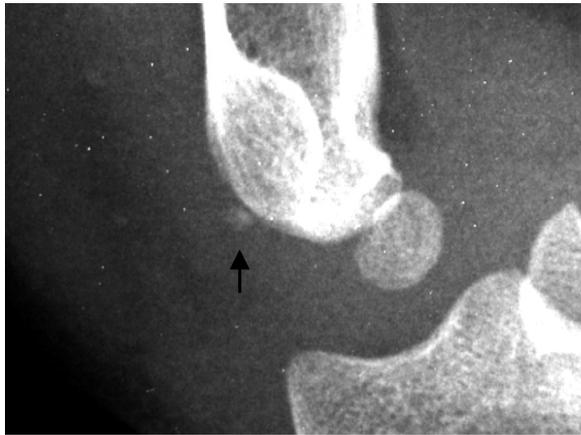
Lateral radiograph of the right elbow. Soft tissue swelling is mostly posterior with some nodular calcifications, one of which appears intraarticular (arrow).
